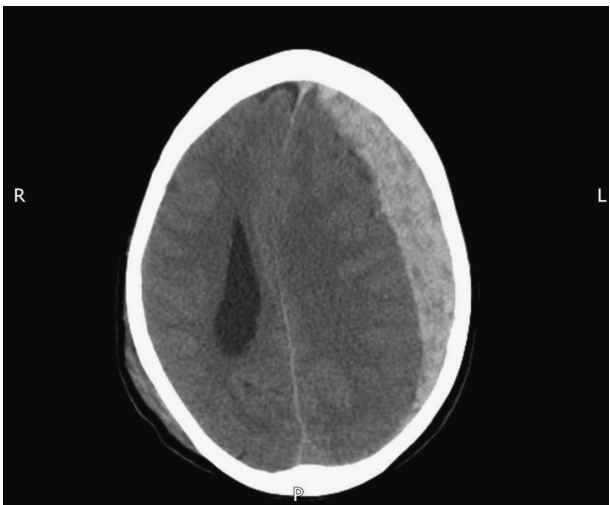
CT showing an acute left subdural haematoma with midline shift. Note the right scalp haematoma.
